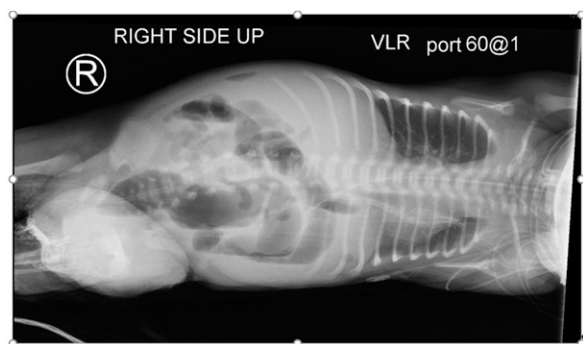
Abdominal radiograph showing gaseous distention of the bowel with free intraperitoneal air on day 12 after birth.
